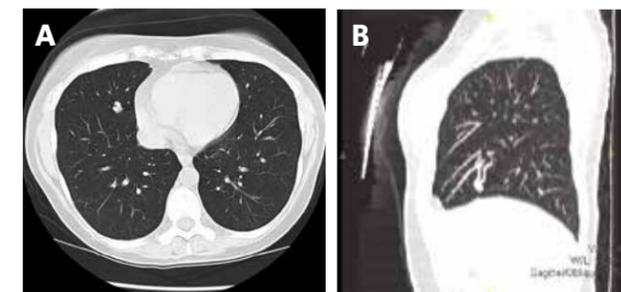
Small pulmonary AVM in right middle lobe on the transverse section CT images (A). Note that the feeding artery and draining vein are better seen on the sagittal reconstruction images (B).
